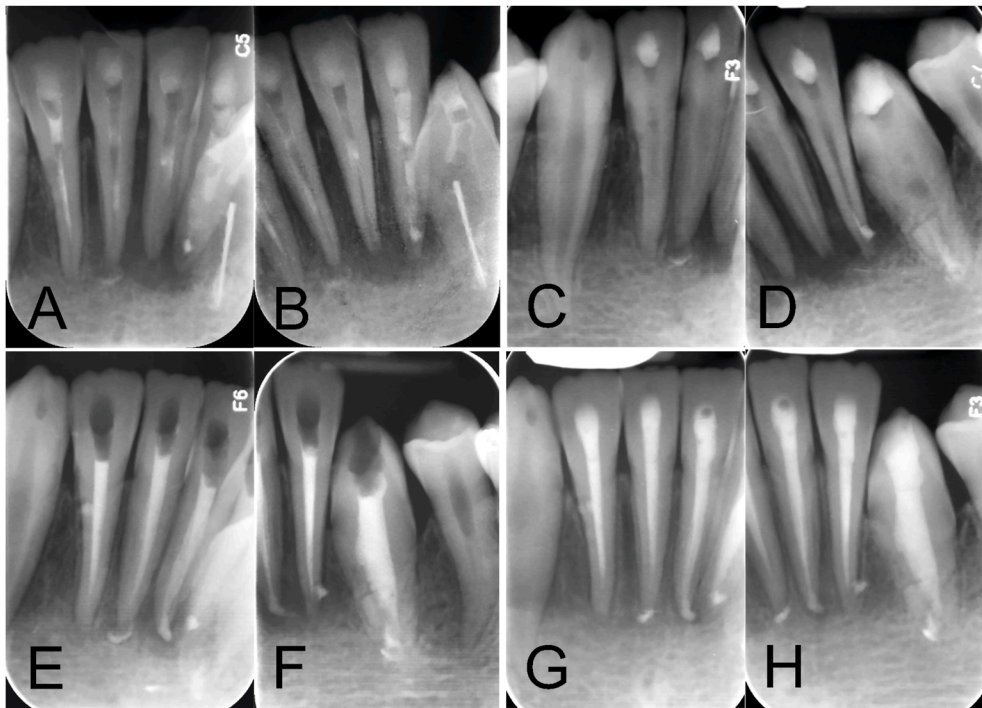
Radiographic progression of mandibular anterior teeth managed with bio-obturation using calcium-enriched mixture (CEM) cement. (A and B) Preoperative radiographs showed incomplete root canal treatment, extensive periapical radiolucencies, severe external root resorption of tooth 42, and a fractured endodontic instrument in the canal of intruded tooth 33. (C and D) Post-instrumentation views demonstrate near-complete removal of intracanal materials, retrieval of the broken instrument from tooth 33, persistent resorptive defects of tooth 42, and a horizontal midroot fracture of tooth 3. (E and F) Immediate post-obturation radiographs confirm complete CEM cement bio-obturation of the canals. Note biomaterial extrusion through a mid-root perforation in tooth 42. (G and H) Six-month follow-up images show complete resolution of periapical lesions and evidence of bony regeneration around all treated teeth.
